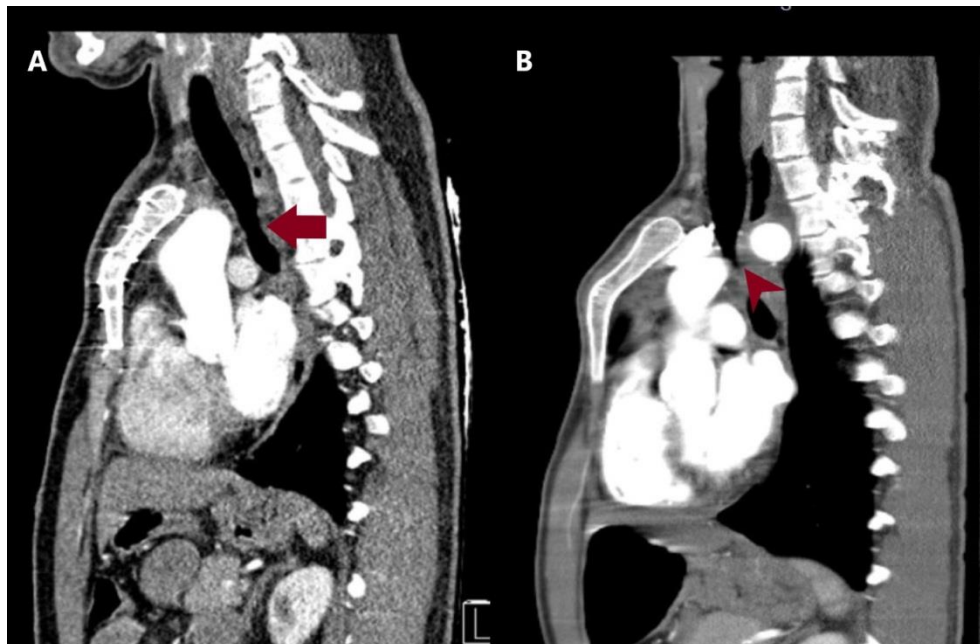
The computed tomography images of the patient after the first operation (B) and after the second operation (A) are presented herein. (A) The tracheal compression has disappeared after extra-anatomic (from ascending to descending aorta) bypass. (B) The tracheal compression continues due to only anterior arch ligation in the first operation.
